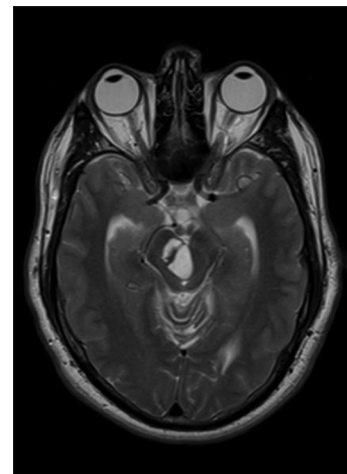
Magnetic resonance imaging axial T2-weighted sequence demonstrating cystic perivascular spaces in midbrain tegmentum with local mass effect on aqueduct of Sylvius
